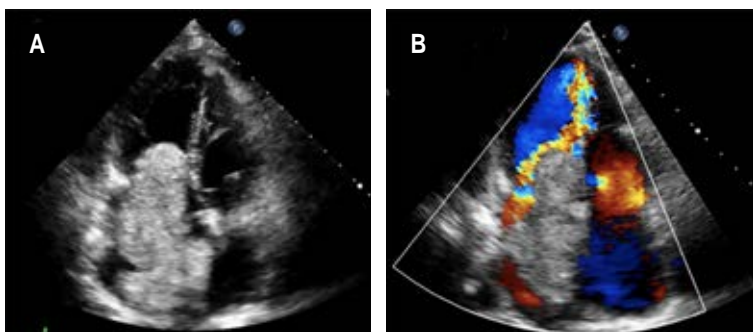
Transthoracic echocardiogram. A) Four-chamber diastole showing a mass in the left atrium protruding through the mitral valve into the ventricle. B) Color Doppler in four chambers.
